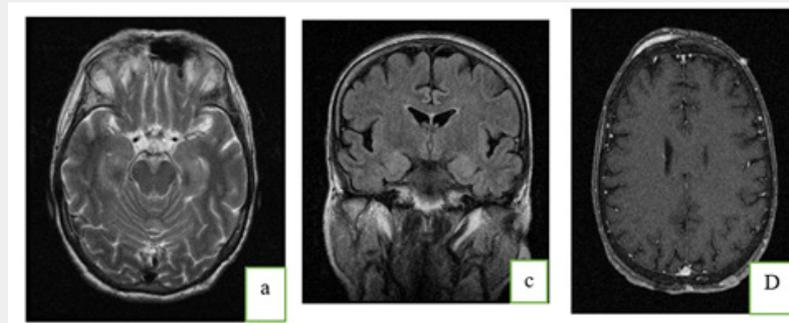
Brain MRI in Axial Cut T2 (a), coronary FLAIR (b) and injected axial (c) showing the presence of multiple nodular lesions under the skin in relation to neurofibroma associated with hippocampal hypertrophy as part of its pathology
